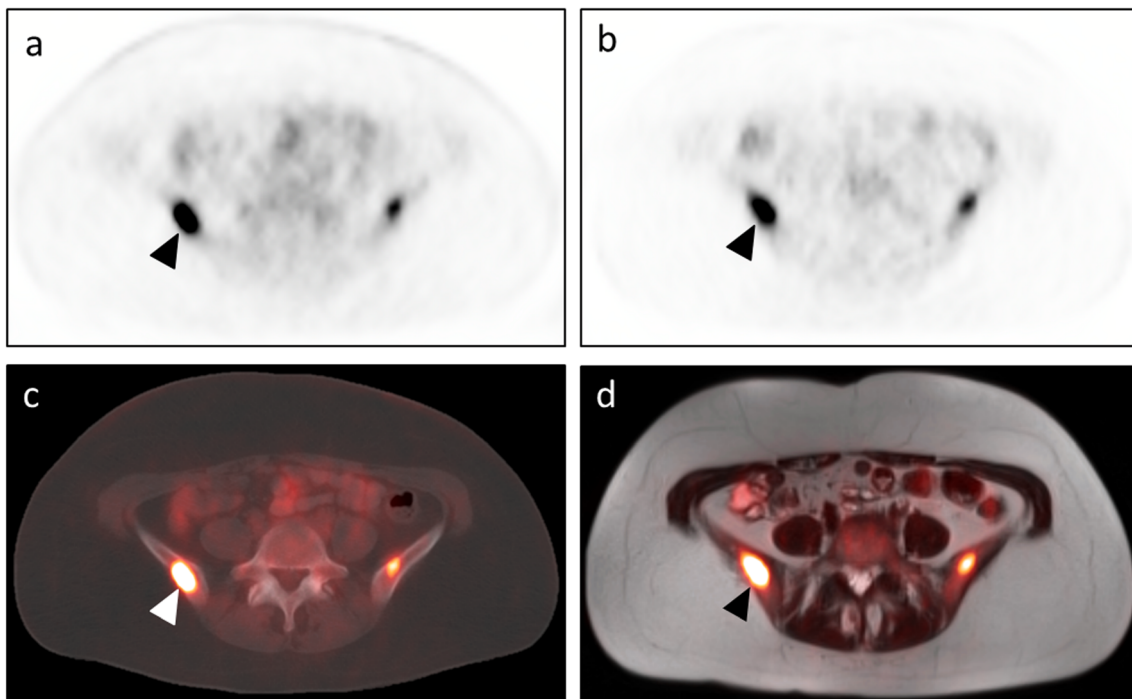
FFBL deemed to be of equal conspicuity on PET images from the PET/CT and PET/MRI datasets by both readers. A 42-year-old man with epithelioid hemangioendothelioma of the right femur status-post percutaneous cryoablation presented for restaging and underwent both PET/CT (a – transaxial PET images; c – transaxial CT images with PET fusion) and PET/MRI (b – transaxial PET images; d – transaxial
